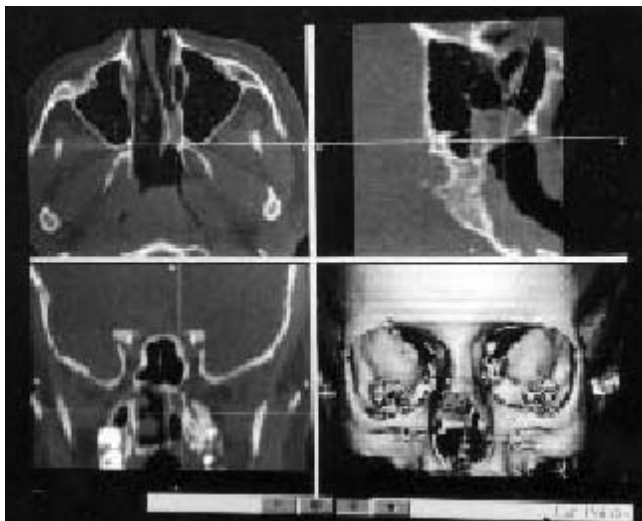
Monitor view (axial, sagittal, coronal view and 3D reconstruction) of a deformity of the septum and a bony unilateral choanal atresia on the left side. The crosshair indicate the position of the pointer tip on the bony plate (good visible on the sagittal view). On the coronal view of the CT is shown impacted teeth on the maxilla, the septum deformation as an absence of the inferior and middle turbinate on the left side [case 2].
